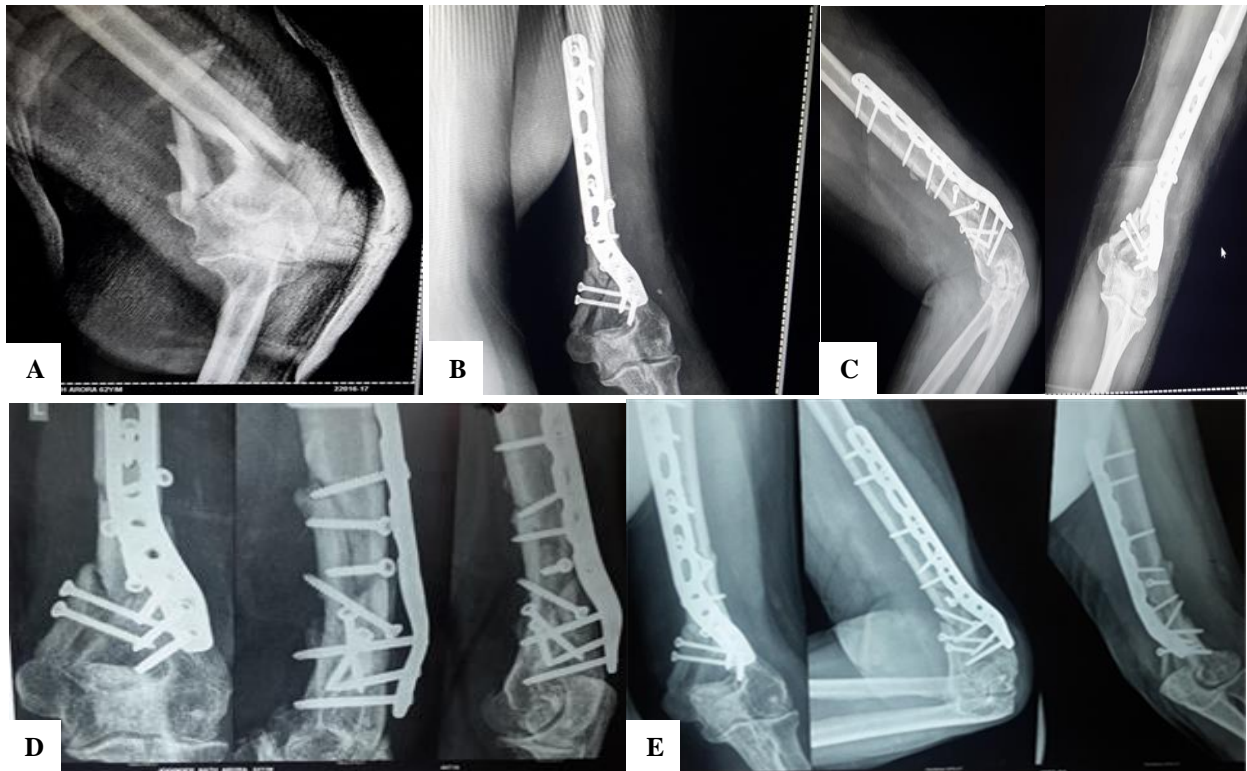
(A) Preoperative radiograph; (B) immediate postoperative; (C) at 6 weeks post op; (D) at 3 months; (E) at 6 months.
